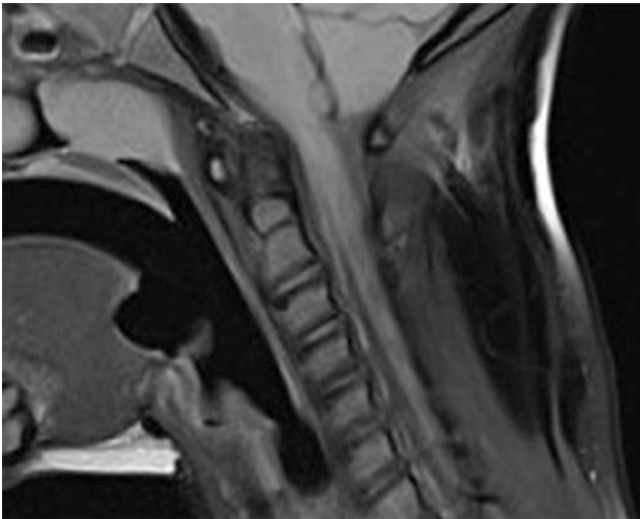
Boy, aged 5 years, with Gardner syndrome presenting a cervical aponeurotic fibroma with very low signal on MRI
